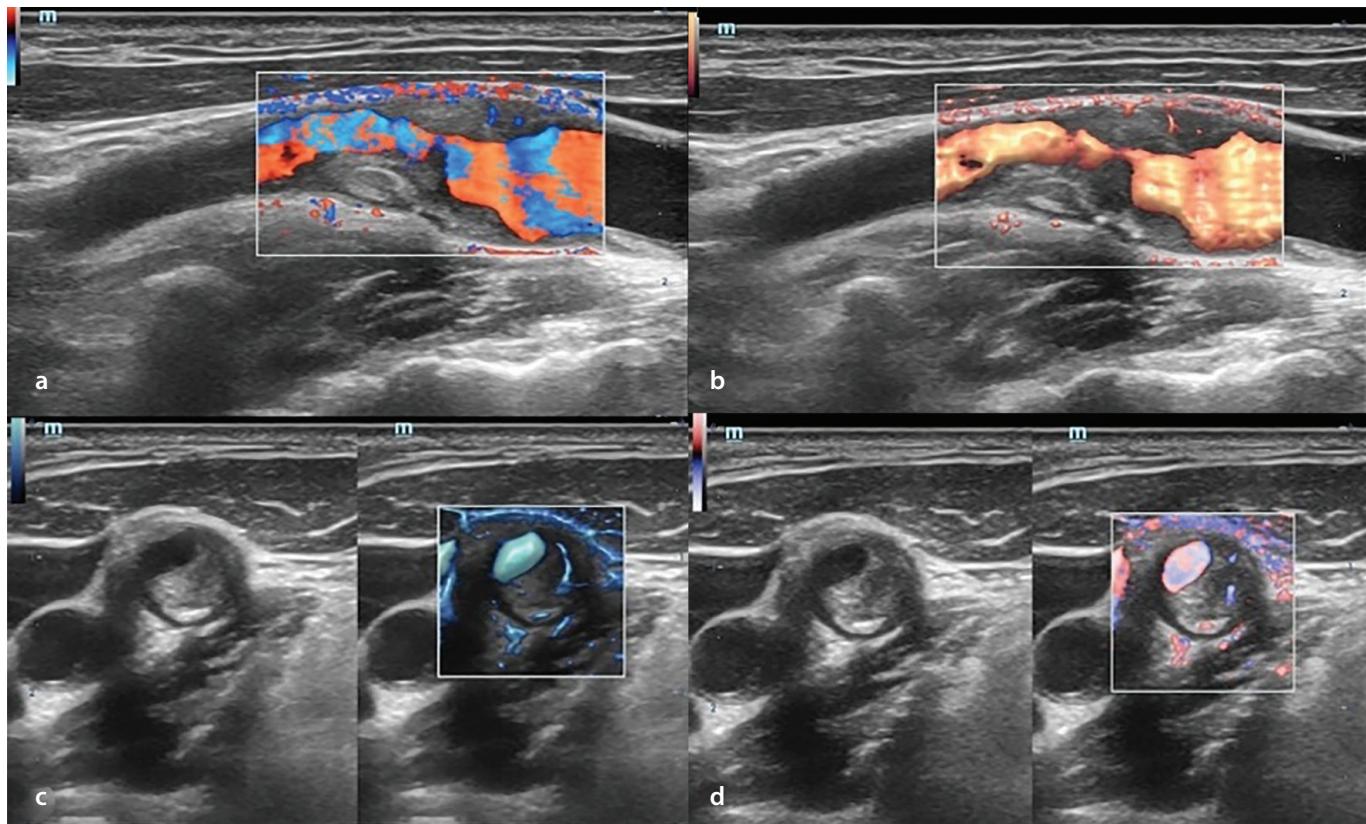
Microvascular ultrasound (US) imaging findings in complex plaques in the carotid bulb and proximal internal carotid artery causing high-grade carotid stenosis. Microvessel US imaging with different hues in longitudinal (a, b) and axial views (c, d) reveal tiny vessels at the anteriorly located plaque, representing neoangiogenesis.
